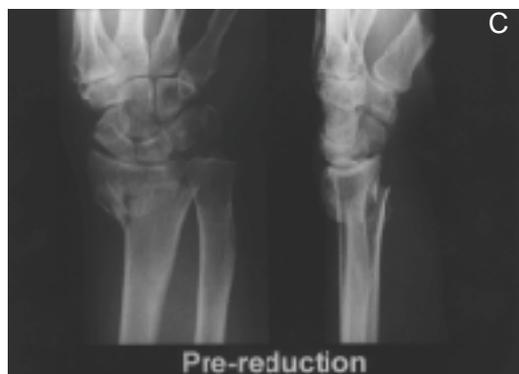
Initial X-rays (21-year old male) show dorsally displaced extraarticular fracture of the distal radius.
